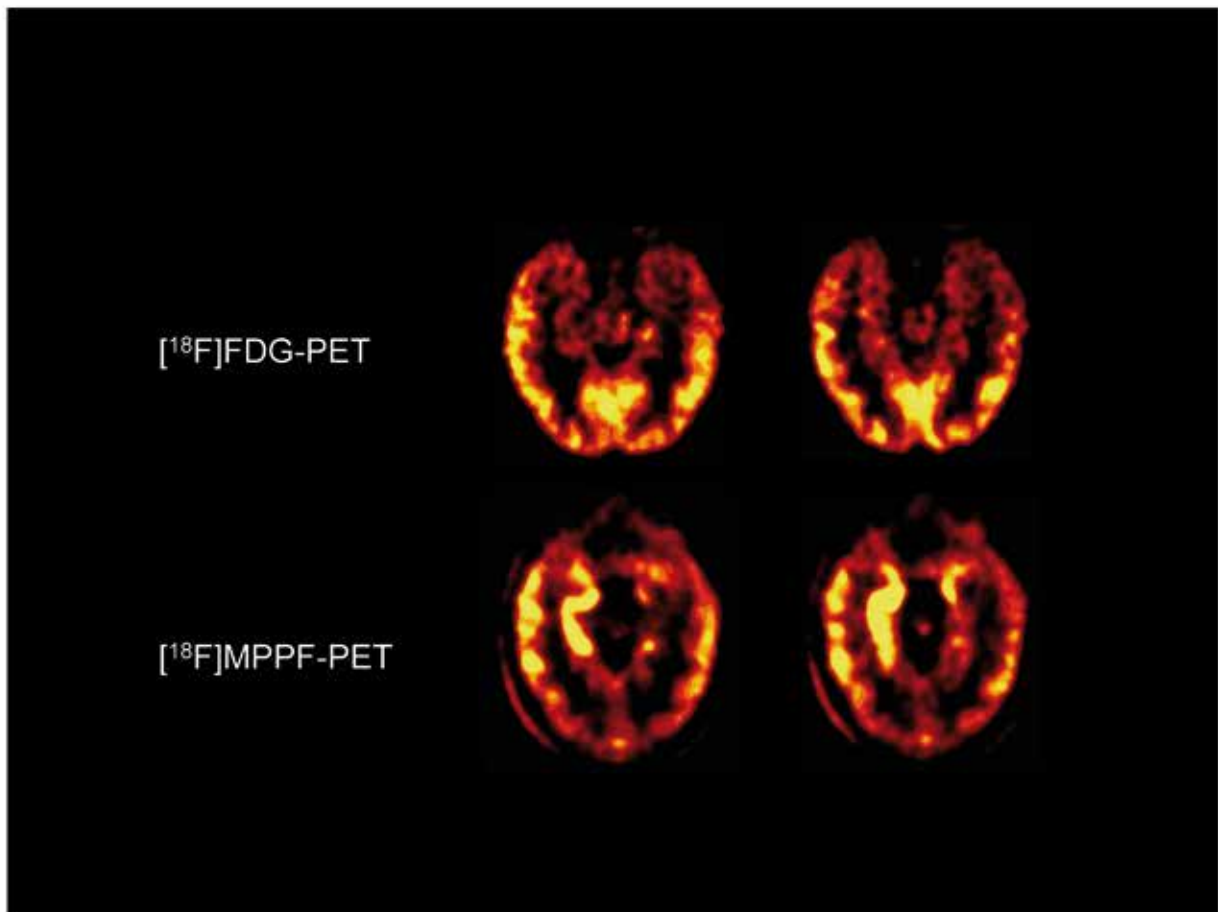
[^{18}F]-FDG PET and [^{18}F]-MPPF PET in a patient with a temporo-limbic epilepsy and normal MRI: the images show a slight decrease in FDG uptake and a clear and severe MPPF binding reduction located within the left temporal region. (Courtesy of Prof. P. Ryvlin)
